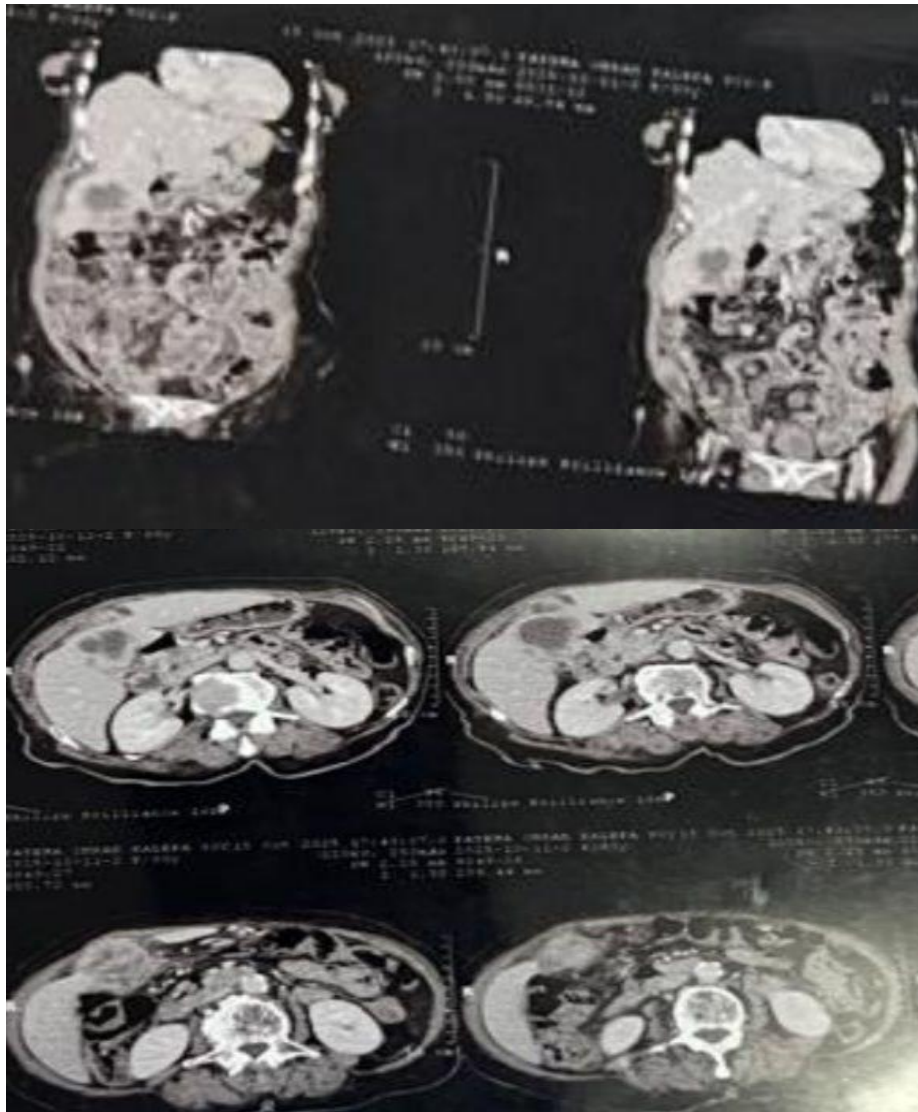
Computed tomography imaging showing xanthogranulomatous cholecystitis. Coronal(A) and axial (B)scans of the abdomen display diffuse thickening of the gallbladder wall; the border between the gallbladder and liver is indistinct.
